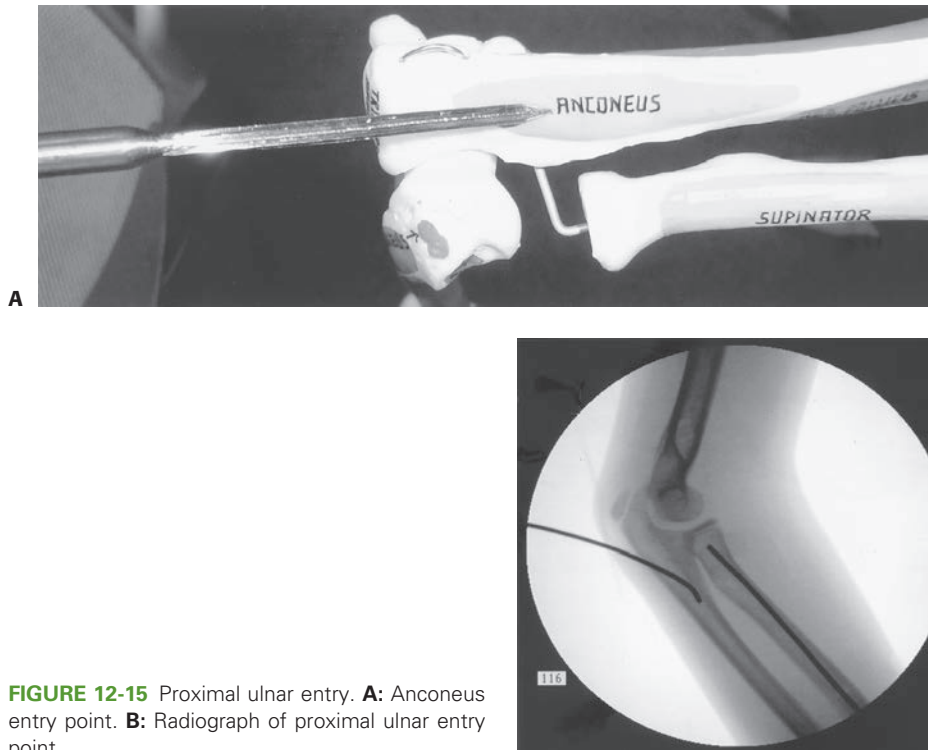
Proximal ulnar entry. A: Anconeus entry point. B: Radiograph of proximal ulnar entry point.
